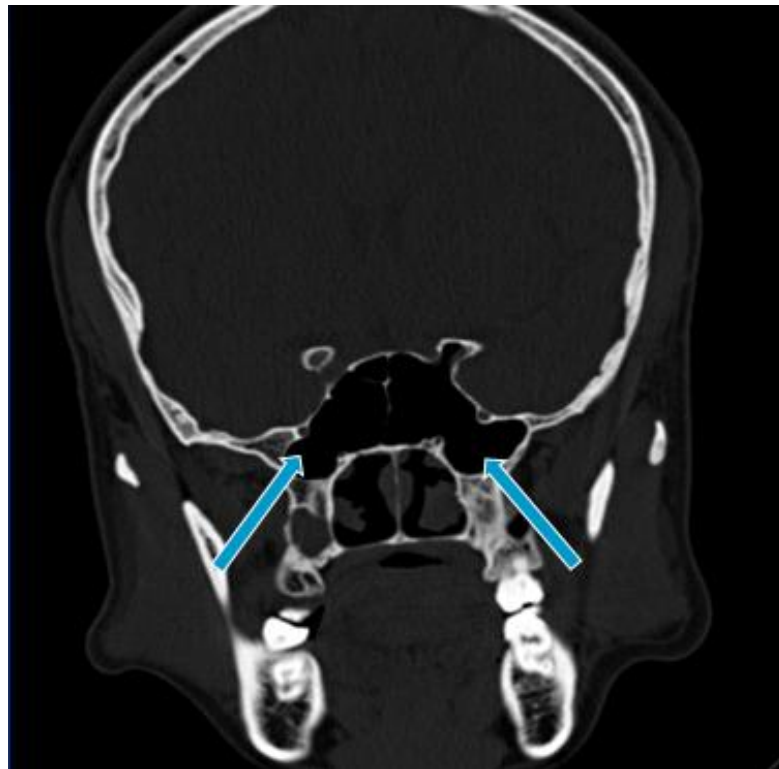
CT coronal section of sphenoid sinus showing pneumatization of bilateral pterygoid processes.
